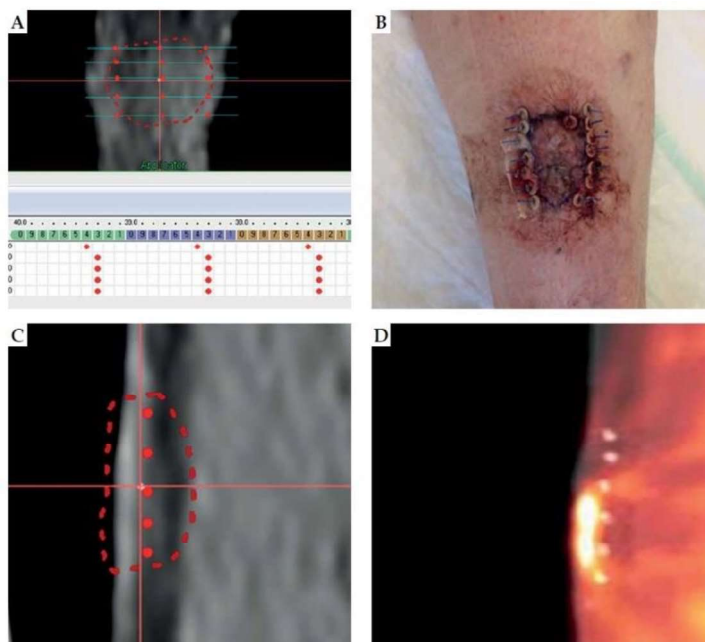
The treated lesion B that has grown from treatment planning session; B) The pretreatment planning session, 5 needles of 2 seeds spaced between each other of about 3-4 mm to account for lesion swelling were foreseen for the CTV. The implant resulted in 7 needles with 2 seeds, 1 needle with 1 seed, for a total of 15 seeds. This underlines the importance of having spare needles before starting a procedure; C) Saggital view of the treatment planning; D) The fusion between preplanning PET and after treatment CT. An evident lesion growth between PET scan and intervention day
